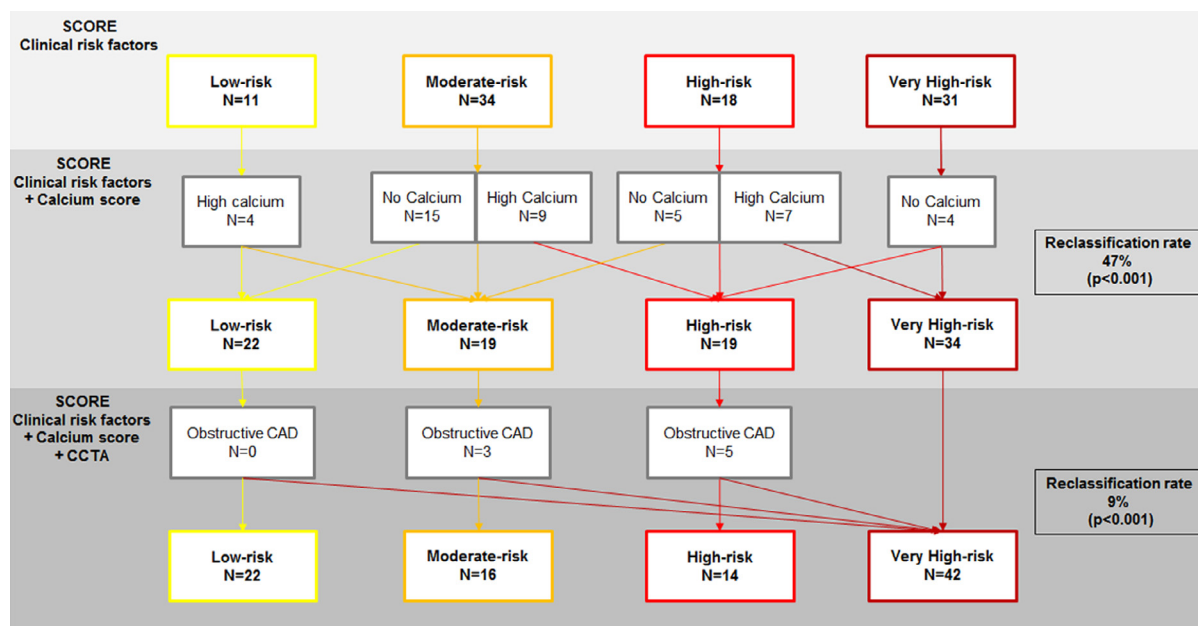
Cardiovascular risk stratification of AF patients based on clinical patient characteristics, calcium score, CCTA findings. A reclassification rate was calculated as a proportion of patients who were reclassified after the implementation of the coronary calcium score and CCTA findings and statistically tested by chi-square tests. AF = atrial fibrillation; CAD = coronary artery disease; CCTA = coronary computed tomography angiography.
